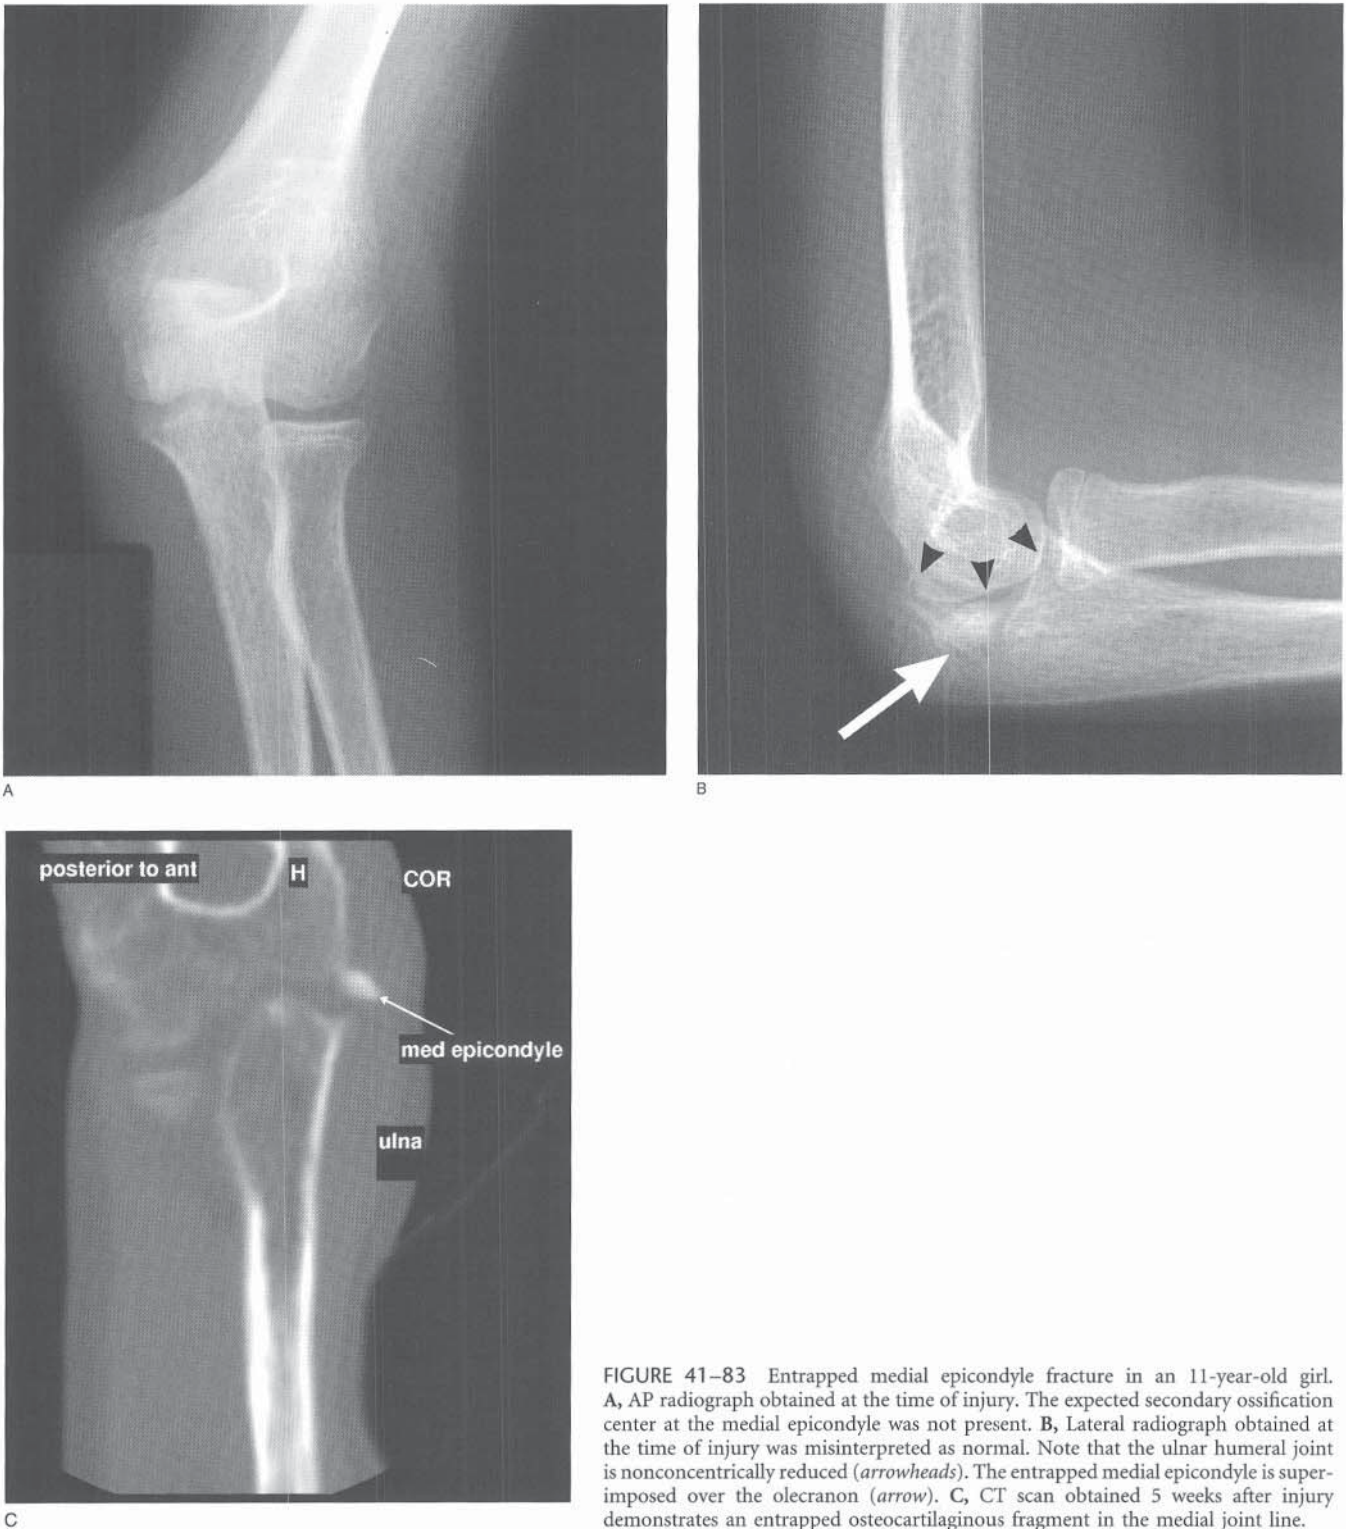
Entrapped medial epicondyle fracture in an 11-year-old girl. A, AP radiograph obtained at the time of injury. The expected secondary ossification center at the medial epicondyle was not present. B, Lateral radiograph obtained at the time of injury was misinterpreted as normal. Note that the ulnar humeral joint is nonconcentrically reduced (*arrowheads*). The entrapped medial epicondyle is superimposed over the olecranon (*arrow*). C, CT scan obtained 5 weeks after injury demonstrates an entrapped osteocartilaginous fragment in the medial joint line.
